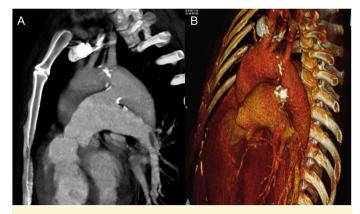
Two- and three-dimensional thorax CT shows a large PDA. CT, computed tomography; PDA, patent ductus arteriosus.
